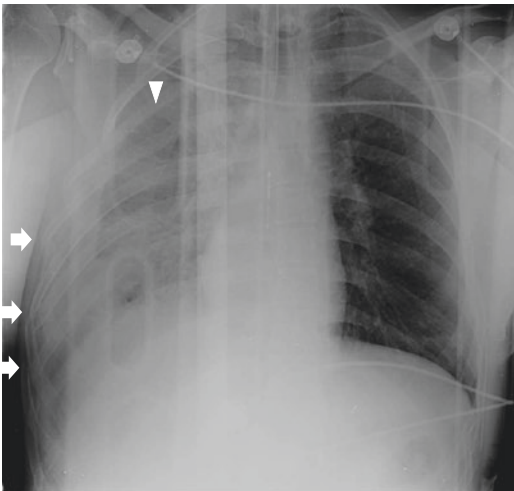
Chest X-ray performed in shock room in supine position on the spinal board, in a patient who underwent a severe chest trauma after a MVA, showing subcutaneous emphysema of the right chest wall, multiple rib fractures (*arrows*), lung contusions (*arrowhead*). Endotracheal tube placement
